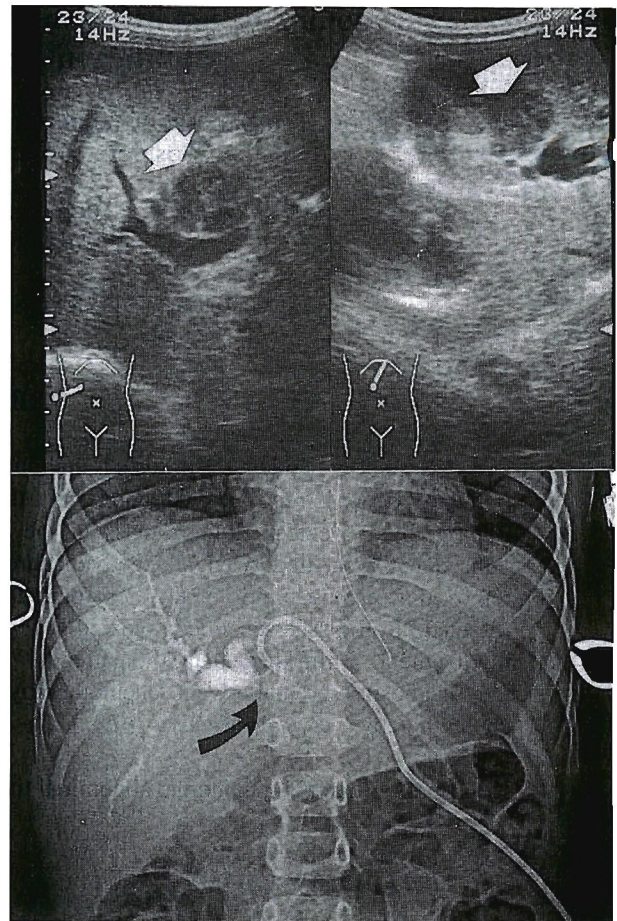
Abdominal ultrasonography revealing a hypoechoic tumor in the porta hepatis (top; arrows) and PTC using a drainage tube showing a smooth occlusion of the hepatic duct (bottom; arrow).
